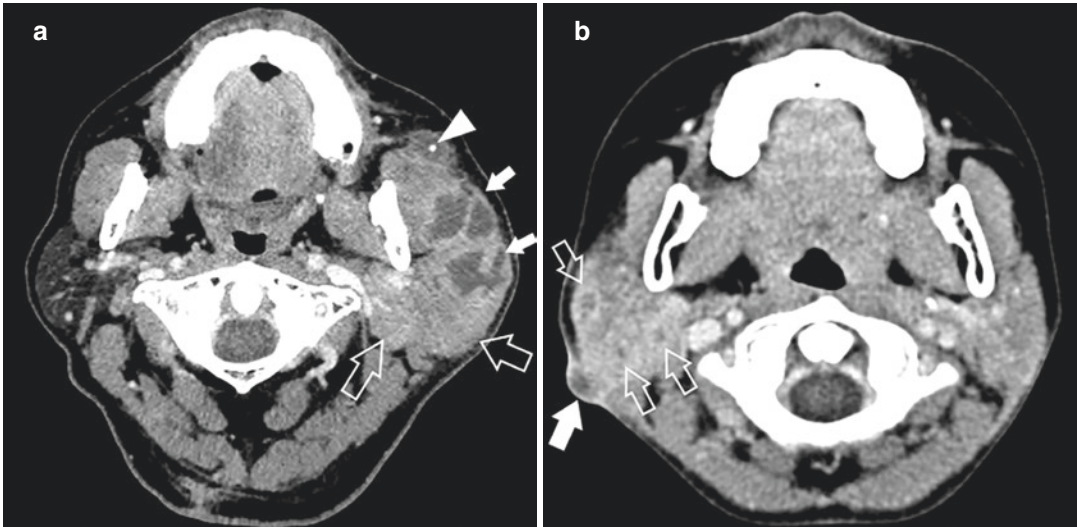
Parenchymal and lymph node involvement in parotid tuberculous in two different patients. (a) Axial contrast-enhanced CT image shows diffuse enlargement and increased enhancement of the left parotid gland (open arrows) with multiple parotid lymph nodes showing irregular thin rim enhancement with central necrosis (small solid arrows). A small round calcification (arrowhead) is present in a necrotic lymph node within an accessory
